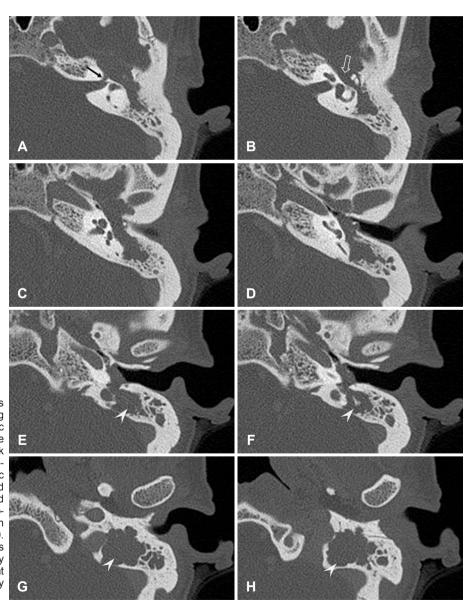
Axial temporal bone CT scans show soft tissue density extending from labyrinthine portion to tympanic to mastoid portion of the facial nerve canal. The labyrinthine segment (black arrow) of the facial nerve canal appeared widened (A). The epitympanic space (empty arrow) was widened and ossicles appeared to be pushed laterally and the geniculate fossa showed bulbous enlargement filled with the soft tissue density (B, C and D). Bony septa of the mastoid air cells appeared destructed and the cavity was filled with soft tissue density that extended from the middle ear cavity (arrowheads)(E-H).
